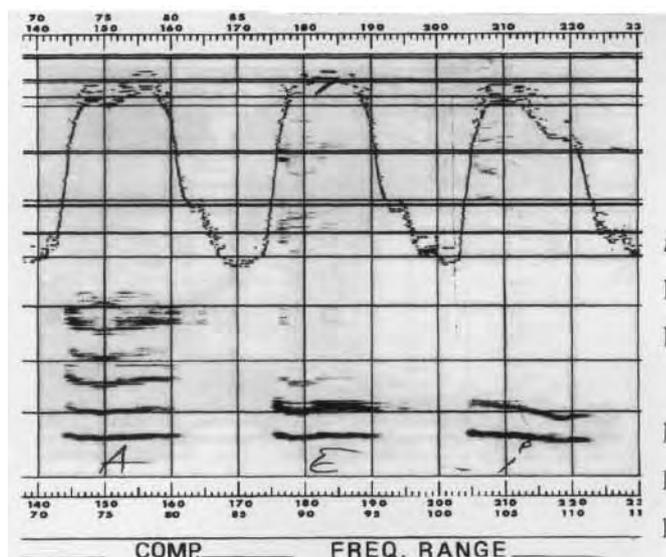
The sonography finding in cordoverventricular voice: vowels a, e, and i
